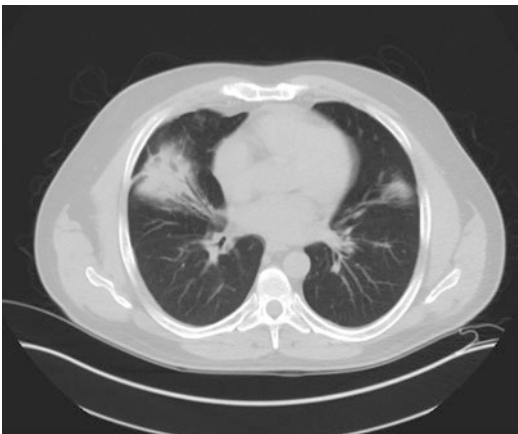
CT imaging of a patient showing alveolar infiltrates consistent with organizing pneumonia. The patient had received a fludarabine conditioning regimen and had no systemic manifestations of GVHD. The patient had no infectious etiologies identified on bronchoalveolar lavage (BAL) fluid testing and had subsequent improvement in symptoms and infiltrates after treatment with corticosteroids
